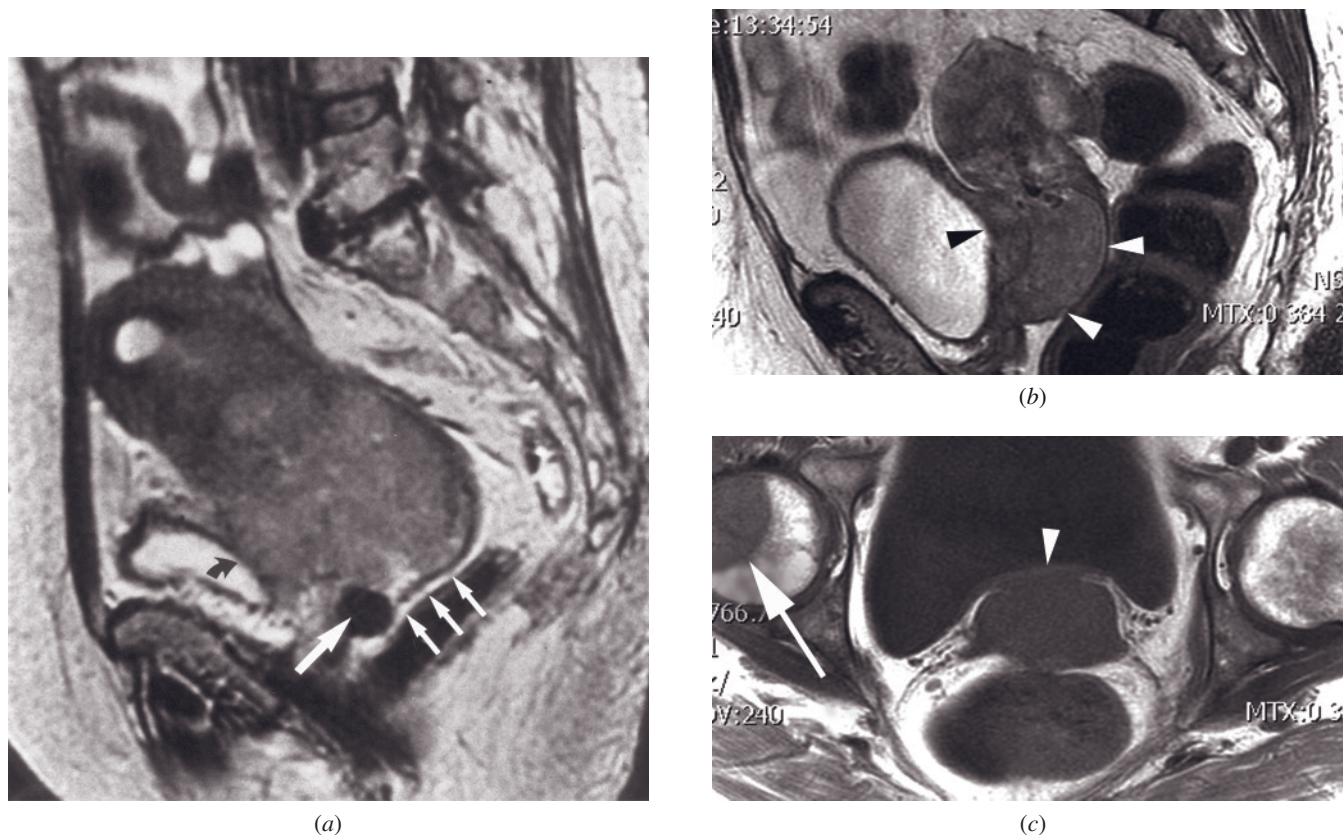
Cervical carcinoma with urinary bladder invasion (FIGO stage IV). (a) Sagittal T2-weighted ETSE image shows hyperintense cervical carcinoma with extension to the vagina (large arrow: tampon) and urinary bladder (curved arrow). Note that the fat plane between cervix and rectal wall is well seen (small arrows), excluding rectal invasion. Stage IV cervical carcinoma at 3T. Sagittal T2-weighted ETSE (b) and transverse T1-weighted gradient-echo (c) images show a large cervical mass (white arrowheads, b) with abnormal thickening of the bladder wall (black arrowhead, b; white arrowhead, c). Stage IV disease was diagnosed based on the large femoral metastasis (arrow, c).
